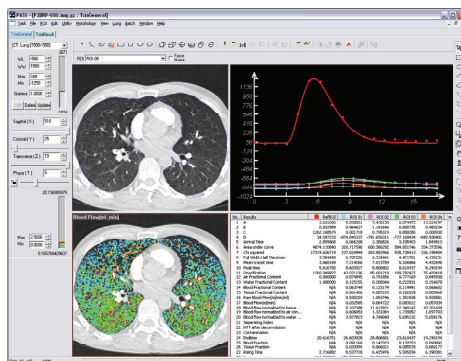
This figure shows a screenshot of PASS using the TSIA Single Image Task using the perfusion algorithm on a human subject who is a smoker with early signs of emphysema on MDCT. Views: Gray scale CT image with user defined ROIs (upper left), Non-linear curve-fitted ROIs (upper right), Colormap of pulmonary blood flow (lower left) and per-ROI calculated perfusion parameters (lower right).
